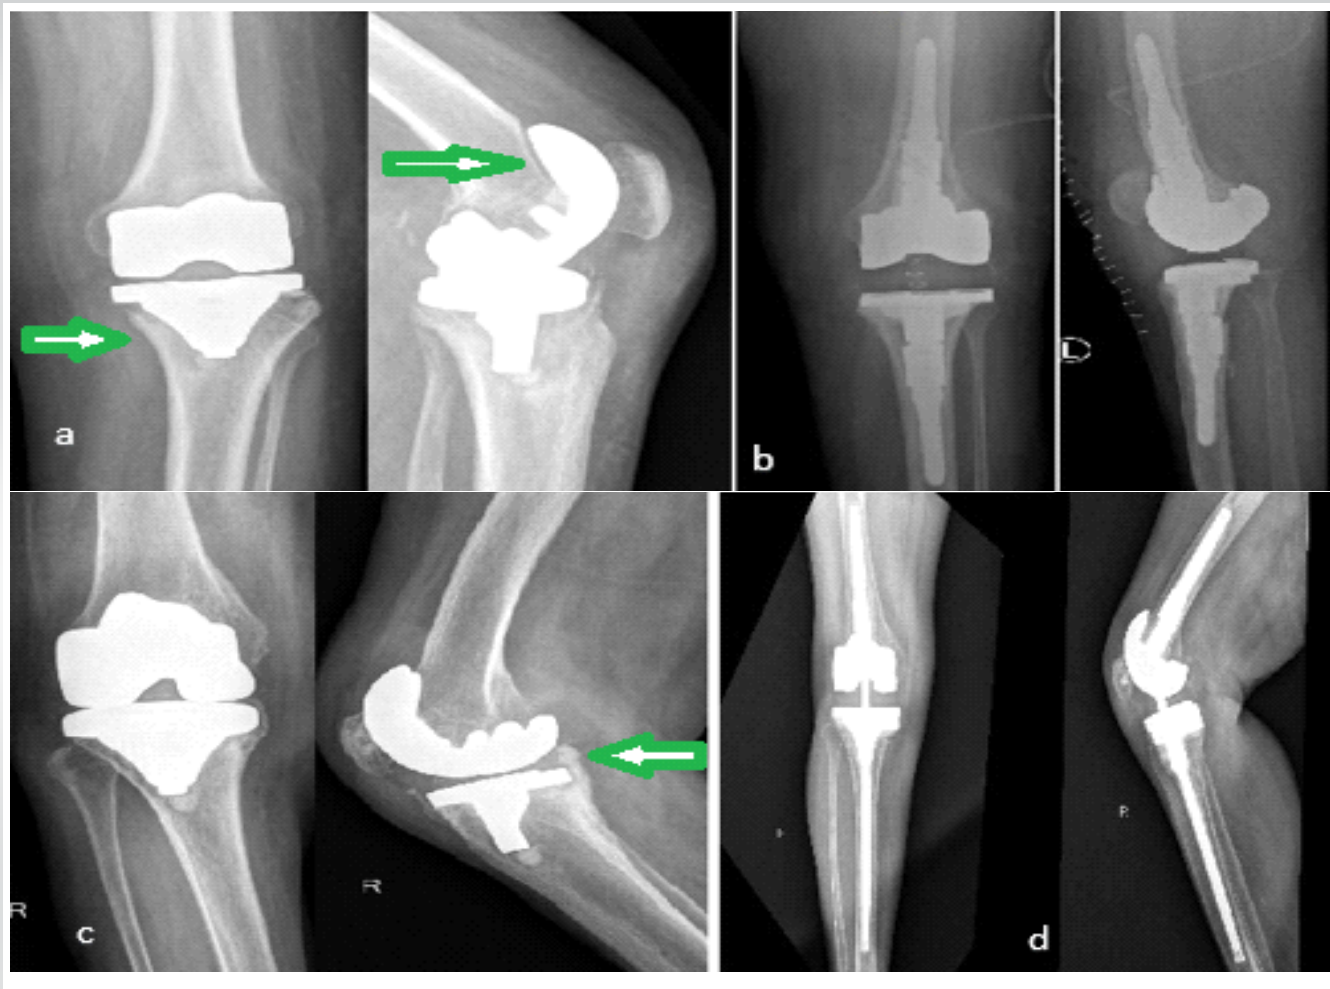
(a) Case 3 pre-operative radiograph showing loosening, (b) 4.5-year follow-up after revision total knee arthroplasty, (c) case 4 infected knee with loosening, (d) 4-year follow-up radiographs of case 4 after revision.
